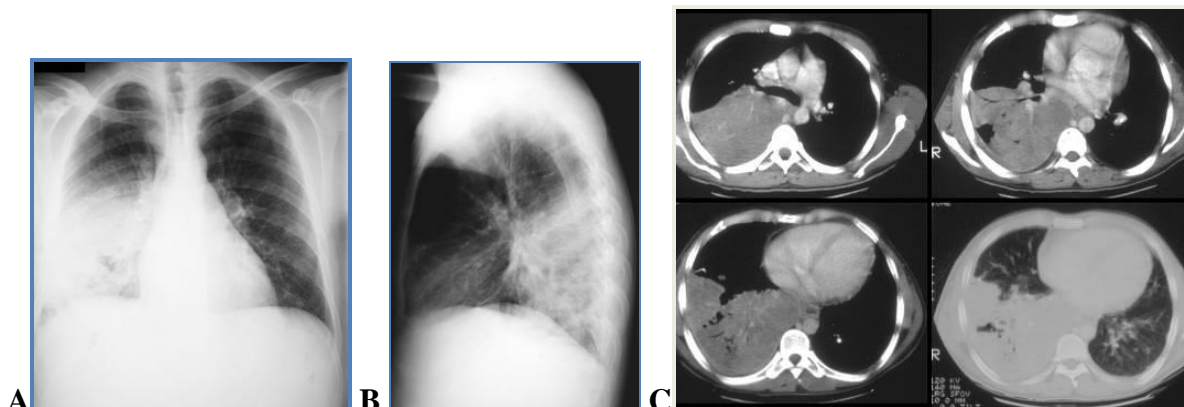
Pneumonia. (A) Frontal chest radiograph, (B) lateral film and (C) CT scans demonstrates a middle lobe airspace opacification with areas of cavitation
